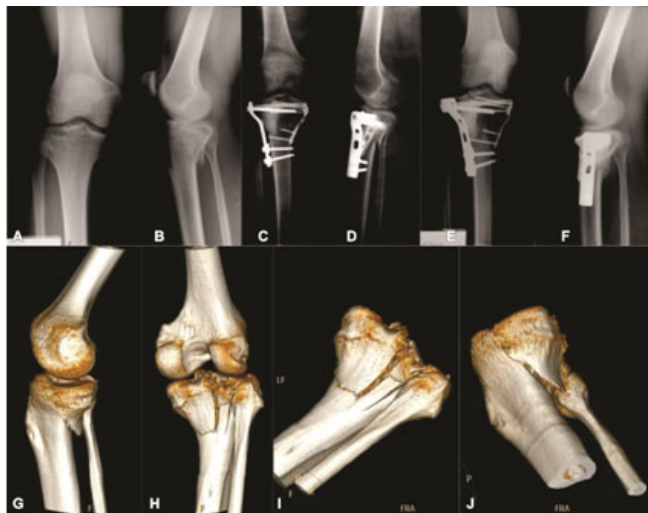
(A-J) Complex fracture of the proximal tibia (type C3/AO). (A,B) Preoperative radiologic aspect (C,D) postoperative radiologic aspect, medial limited approach, reduction and fixation with small T plate, lateral closed reduction filling the bone defect with Eurocer, L plate and screws (E,F) radiologic aspect at 2 months (vanishing of the radiologic gap at bone-biomaterial interface and homogenisation of the bone substitute structure (G-J) preoperative CT with 3D reconstruction
